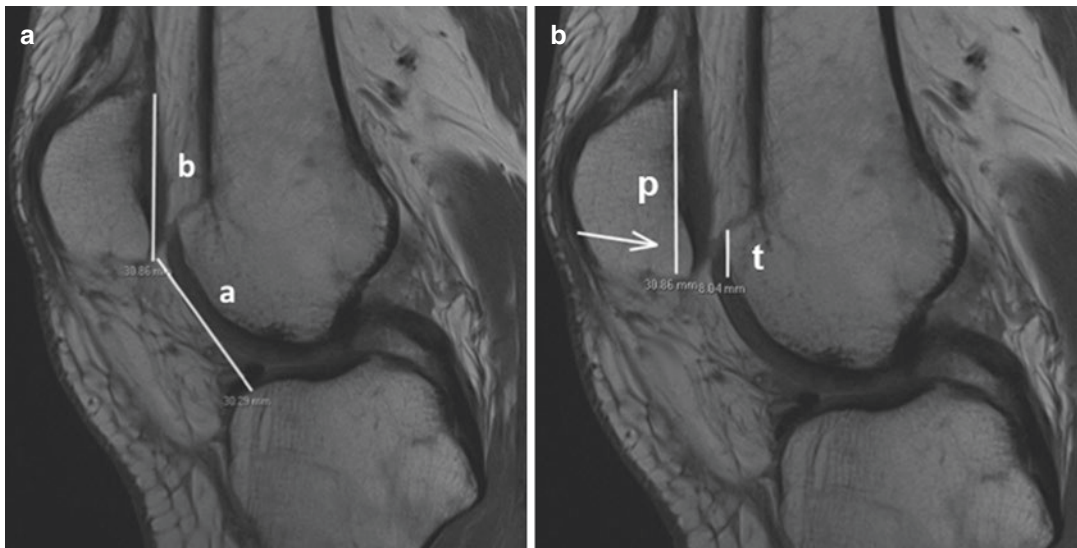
Sagittal MRI with lines drawn to demonstrate (a) CD ratio which is represented as a/b , and (b) PTI which is represented as t/p
